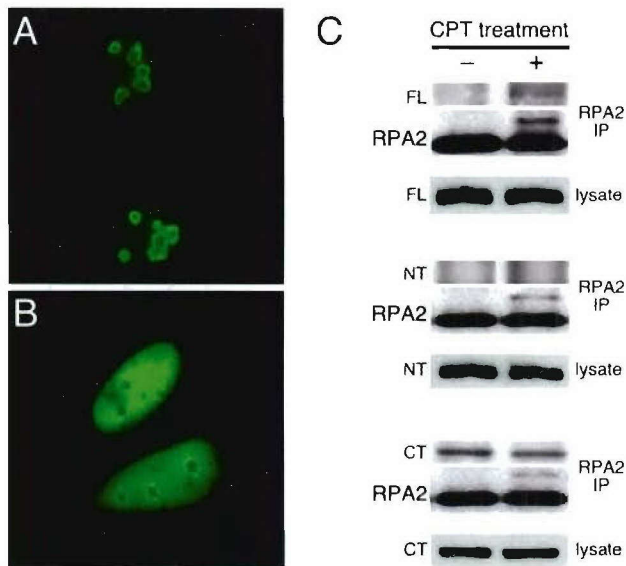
Complex formation between nucleolin FL and endogenous RPA stimulated by genotoxic stress. (A and B) The cellular localization of GFP-tagged nucleolin FL expressed in U2-OS cells is shown in the absence of CPT treatment (A) and after treatment with 1 μ M CPT for 1 h and a 1-h recovery period (B). (C) Immunoprecipitation of endogenous RPA protein with RPA2 antibody in U2-OS cells expressing GFP-tagged nucleolin FL (top set), nucleolin NT (second set), or nucleolin CT (third set). Coprecipitation of the nucleolin proteins was examined in the absence of CPT treatment (–) and 2 h after treatment with 1 μ M CPT for 1 h (+) (upper panels). The same blot was reprobed with RPA2 antibody as a control for RPA immunoprecipitation (middle panels). Lysates were assayed for equivalent expression of GFP fusion proteins by probing with an anti-GFP antibody (lower panels).
